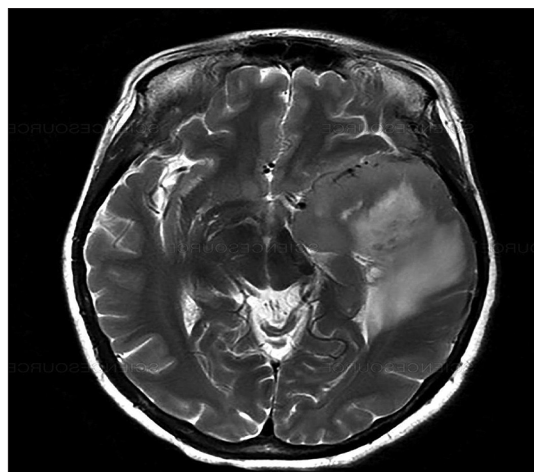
Magnetic resonance imaging of glioblastoma multiforme
